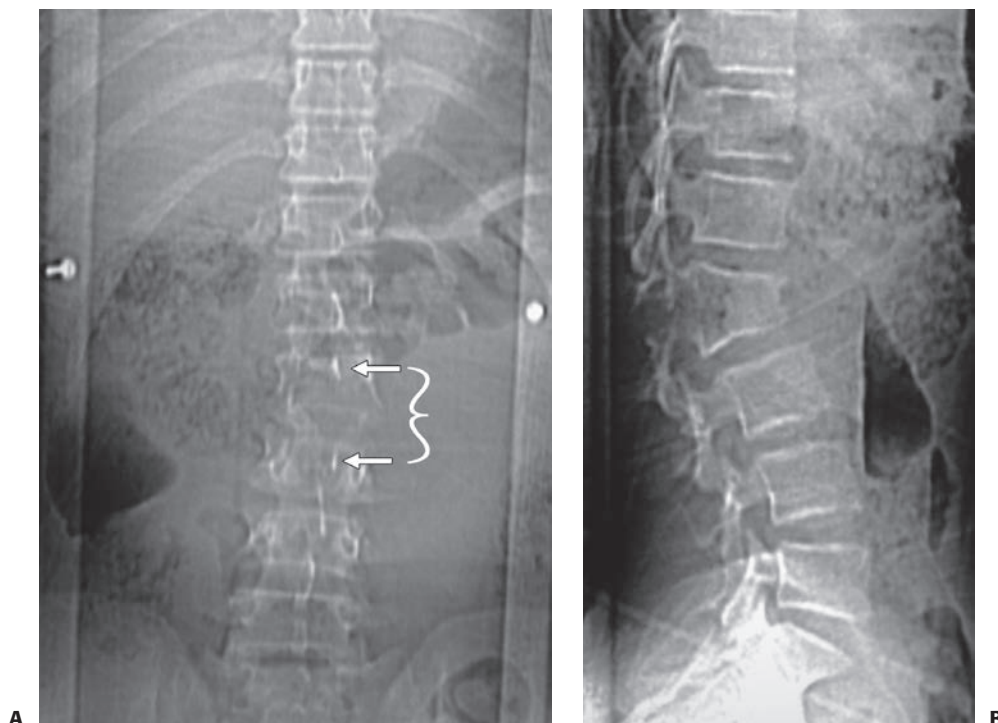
Flexion–distraction injury. A, B: Plain radiographs of a restrained backseat passenger who was involved in a motor vehicle accident. The wedging of L2 with posterior distraction is visible on the lateral radiograph. The intraspinal widening is noted on the AP radiograph as well (*arrows*).
